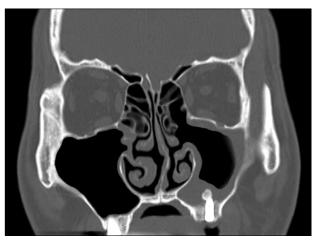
Computed tomography image showing significantly reduced radiopacification after the ostium was widened.
